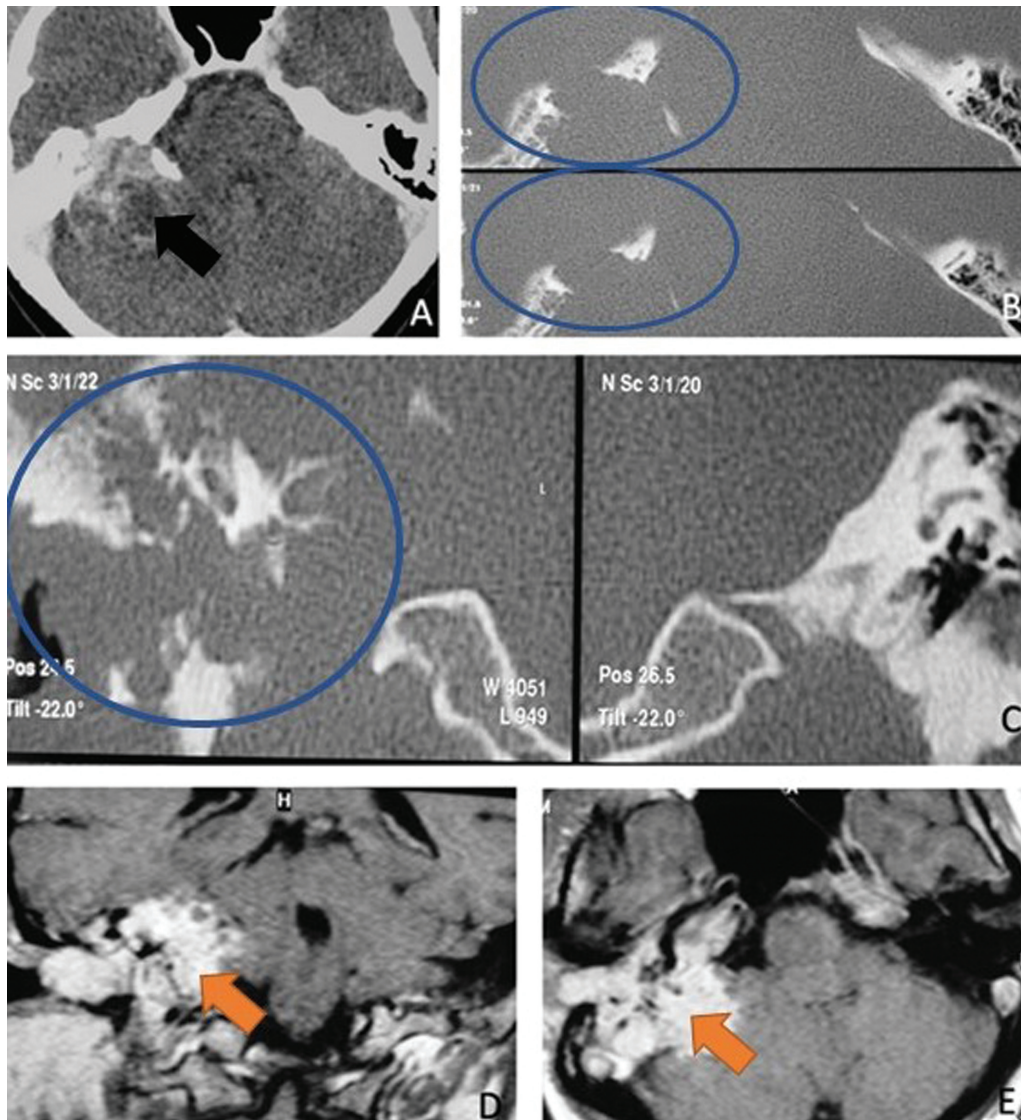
Case 2, CT scan revealed a right angle cerebellopontine tumor, with erosion of the mastoid part of the temporal bone (A). The axial (B) and coronal (C) CT scans in the bone window, showing erosion and destruction of the temporal bone. Coronal (D) and axial MRI scans of the T1 with gadolinium (E) show that the tumor is occupying the mastoid part of the temporal bone with an extension on the cerebellopontine angle and external auditory canal. Black arrow: cerebellopontine angle tumor. Blue circles: bone lesion in the temporal bone petrous portion. Orange arrow: expansive lesion seen in MRI.
